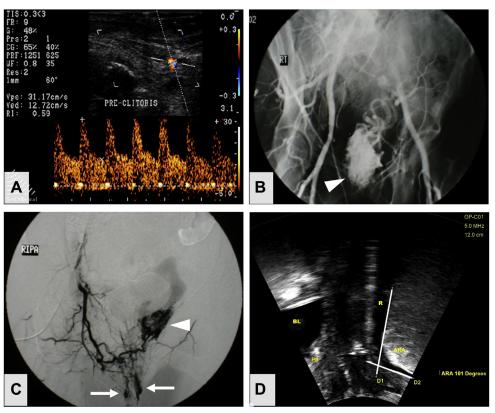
Diagnostic testing in Region 2. A, Color Doppler ultrasound of clitoral cavernosal artery in a woman with lifelong PGAD and left pelvic arteriovenous malformation. B, Aortic arteriogram showing left internal iliac arteriovenous malformation (white arrowhead). C, Selective right internal pudendal arteriogram with visualization of the arteriovenous malformation (white arrowhead) directly communicating with the left and right clitoral corpus cavernosum (white arrows). Visualization of contrast within the clitoral corpora cavernosa, indicating engorgement, is consistent with PGAD symptoms. D, Transperineal ultrasound image showing anorectal angle of 101°, consistent with overactive/hypertonic pelvic floor dysfunction (Image provided by Ramona Horton, PT, DPT). Figure 9 is available in color online at www.jsm.jsexmed.org.
